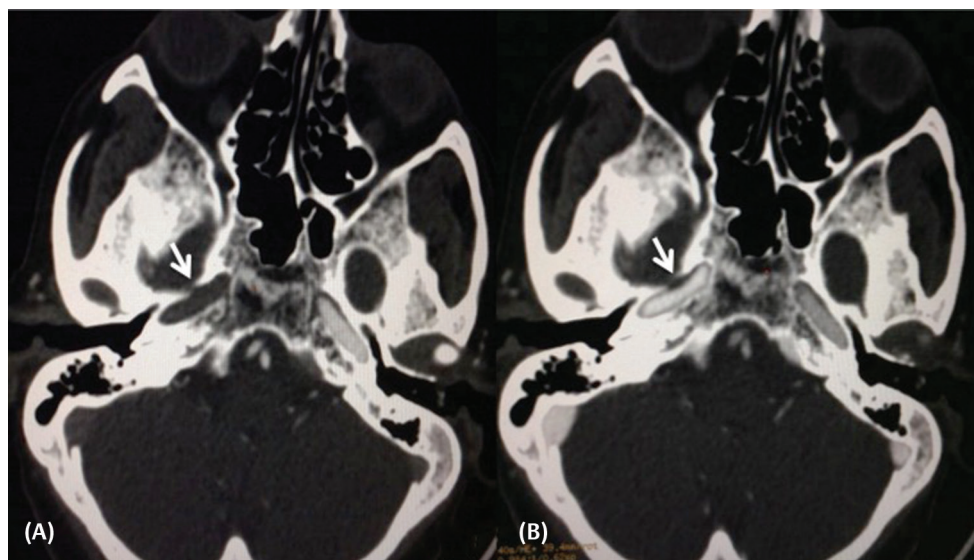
Arterial (A) and venous (B) phase of biphasic computed tomography (CT) angiography demonstrating progressive opacification of the right petrous internal carotid artery (ICA) in the venous phase which was nonopacified in the arterial phase (arrow) signifying “pseudothrombus” and highlighting another use of multiphasic computed tomography (CT) angiography acquisition.
